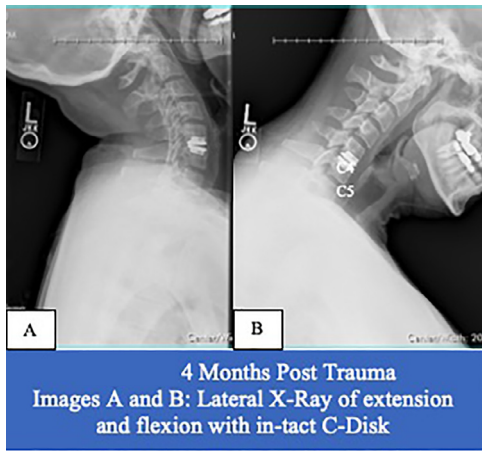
4 Months Post Trauma. Image A and B: Lateral X-Ray of extension and flexion with in-tact C-Disk.
